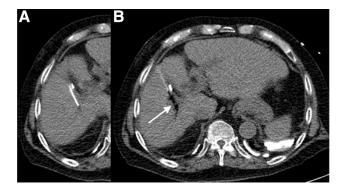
CT image demonstrating needle placement (A) and percutaneous ethanol injection to treat residual tumor (B) with white arrow demonstrating correlating tumor location.
